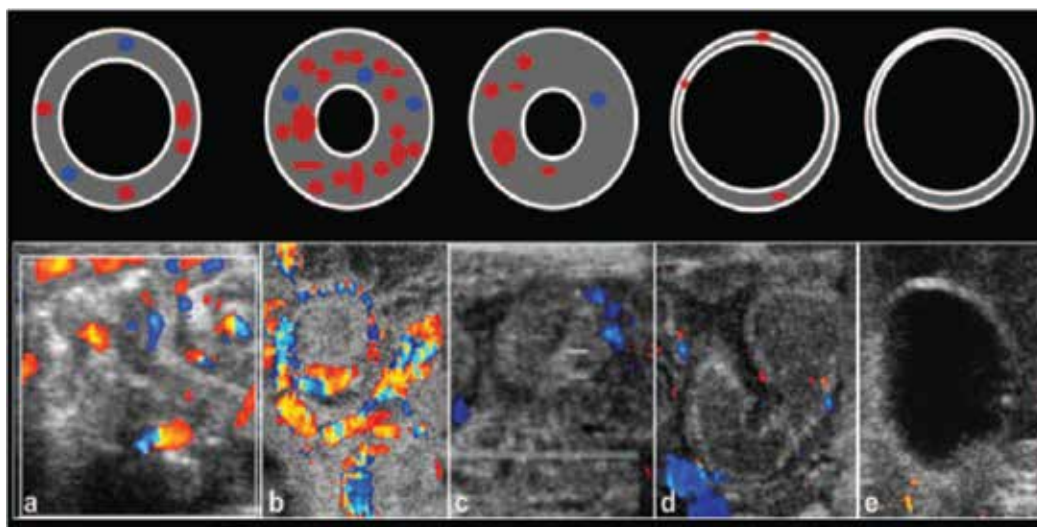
Sonographic appearance of NEC progression (figure from Epelman et al. 38 need permission).
